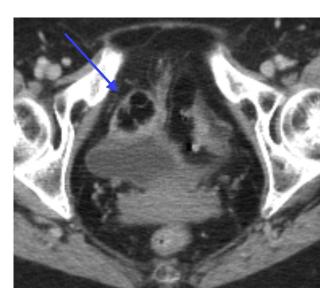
Appearance of fat necrosis (blue arrow) approximately 3.5 months after the first post-operative CT scan.
